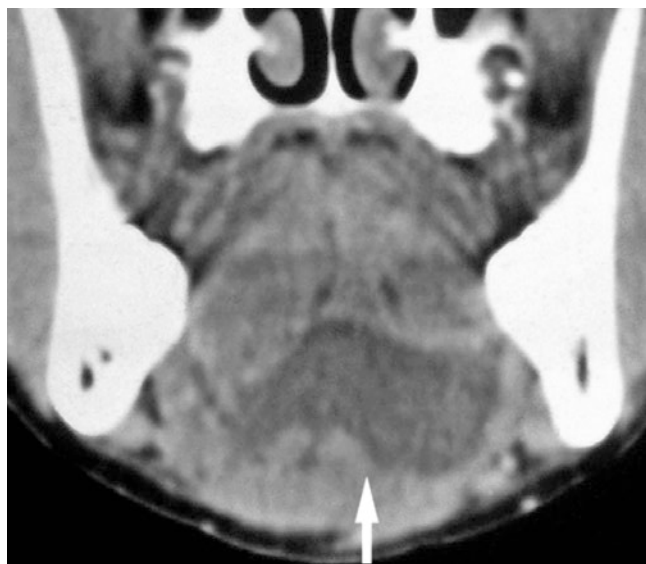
Cystic lymphatic malformation; 14-year-old female with submental swelling. Coronal post-enhanced CT image shows well-defined mass in sublingual space crossing midline (arrows), hypodense with enhanced border
